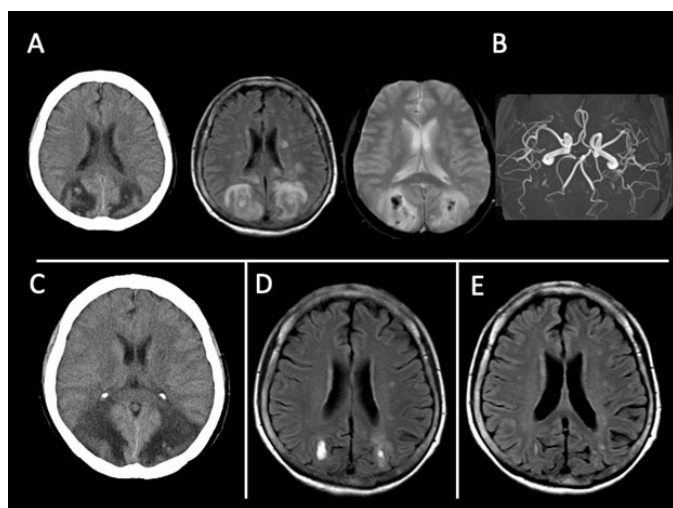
Head CT and MRI findings (Case 2). (A) Head CT, FLAIR, and T2* at onset. (B) MRA at onset. There was no occlusion or stenosis of the vessels, including bilateral PCA. (C) CT taken on day 2. (D) FLAIR at one month after onset. (E) FLAIR taken at three months after onset. CT, computed tomography; MRI, magnetic resonance imaging; MRA, magnetic resonance angiography; FLAIR, fluid-attenuated inversion recovery.
